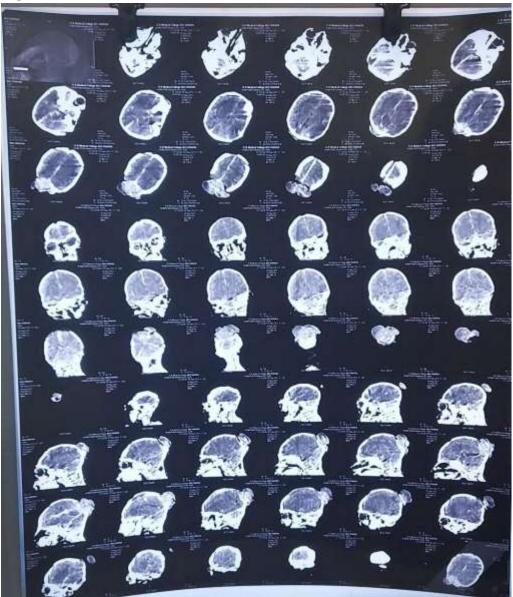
3D CT RECONSTRUCTION OF BRAIN
